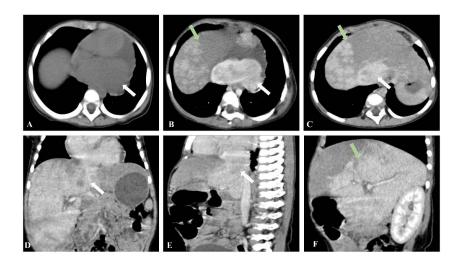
Contrast enhanced CT through level of IMT (1A: Axial section of Plain phase; 1B: Axial section of Arterial phase; 1C: Axial section of Portal venous phase; 1D: Coronal section of Portal venous phase; 1E: Sagittal section of Portal venous phase; 1F: Another sagittal section of Portal venous phase)
